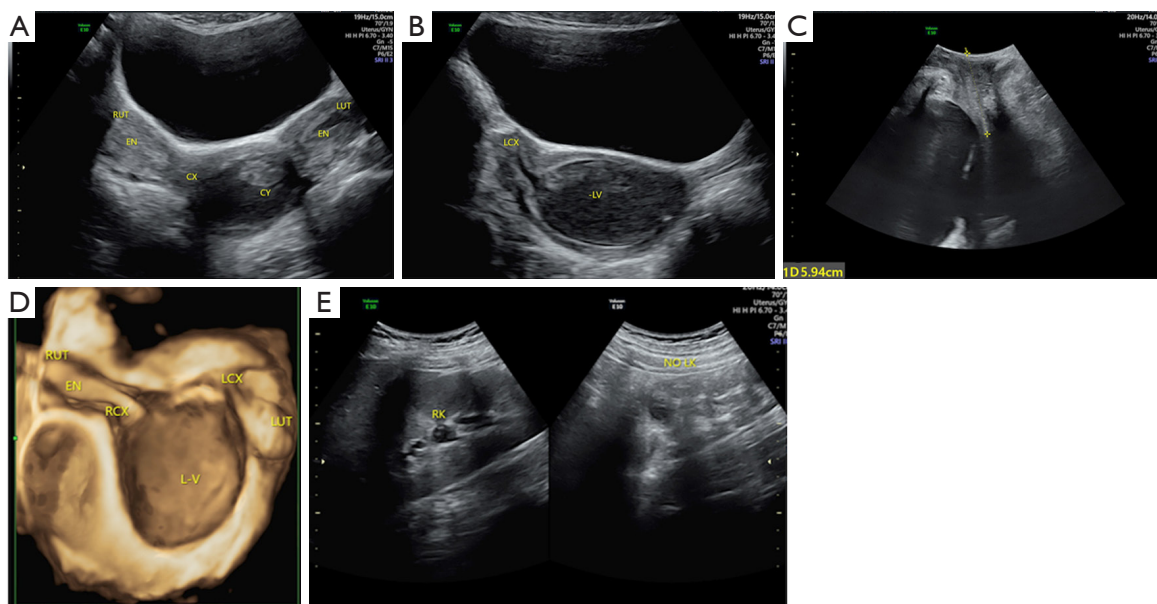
Type I-b UGTOIRA syndrome: U3b-C2-middle OVS, complete bicorporal uterus, double cervix without cervical obstruction, with left middle OVS (without communication observed intraoperatively), and left renal agenesis. Sonograms were obtained from a 12-year-old female patient. (A) TAS 2D coronal plane demonstrating the right normal uterus, cervix, and vagina, and left normal uterus, cervix with keratocele, and middle OVS with a large amount of hematocele in the posterior space of the OVS. (B) TAS 2D sagittal plane of the left uterus-cervix-vagina demonstrating a small amount of hematocele in the left uterine cavity and cervical canal, and a large amount of hematocele in the posterior space of the OVS. (C) TPS 2D sagittal section of the perineum demonstrating that the lower edge of the left vaginal hematocele is 5.9 cm from the perineum. (D) TAS 3D coronal plane of the uterus-cervix-vagina under stereoscopy demonstrating a complete bicorporal uterus, double cervix, and the left middle OVS with a large amount of hematocele in the posterior space of the OVS. (E) TAS 2D sagittal planes identifying the absence of the left kidney (NO LK; right side of the figure) and a right normal kidney (RK; left side of the figure). RUT, right uterus; EN, endometrium; CX, cervix; CY, cyst; LUT, left uterus; LCX, left cervix; LV, left vagina; RCX, right cervix; RK, right kidney; LK, left kidney; UGTOIRA, unilateral genital tract obstruction with ipsilateral renal anomaly; OVS, oblique vaginal septum; TAS, transabdominal sonography; 2D, 2-dimensional; 3D, 3-dimensional; TPS, transperineal sonography.
